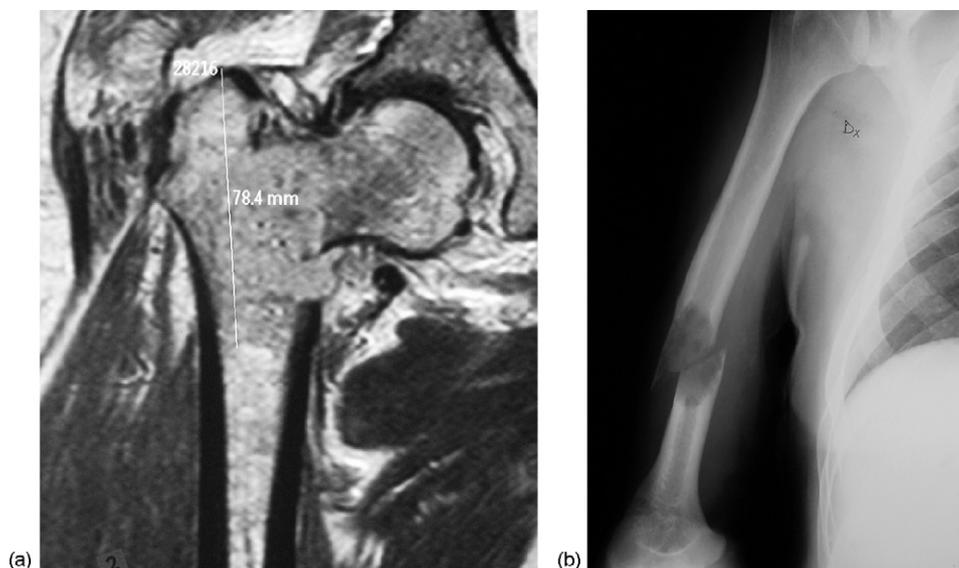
CT scan showing the right femoral metastasis (a). X-ray showing the right humeral metastasis with fracture (b).
